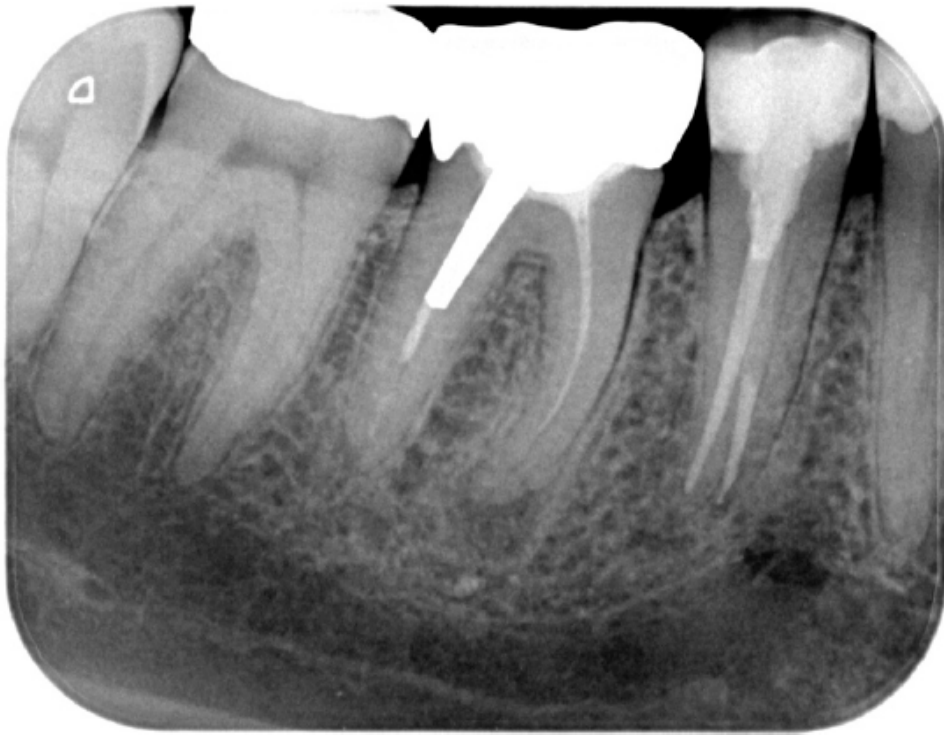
Check-up X-ray image of tooth no. 45 after root canal filling and insertion of an adhesively-anchored glass-fiber pin.
